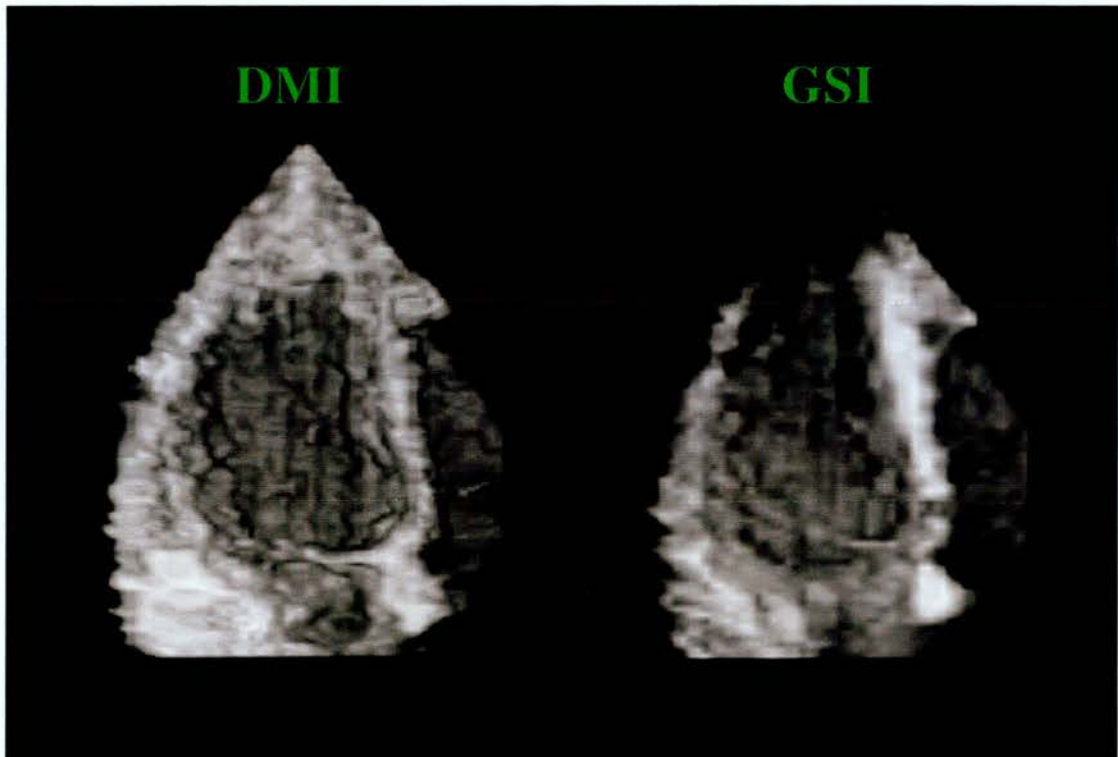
An example of a transthoracic three-dimensional reconstruction of the left ventricle obtained from a 54 year old male with coronary artery disease. Doppler myocardial imaging (DMI) technique on the left side and grey-scale imaging (GSI) technique on the right side of the picture.
